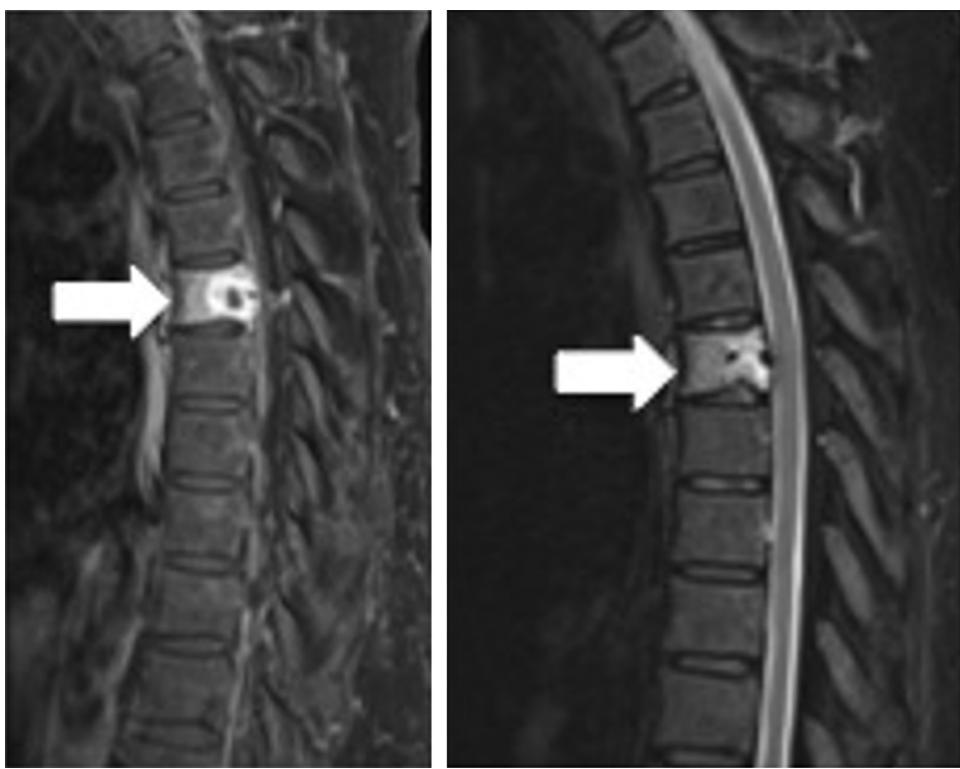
(Left) On follow-up examination 3 months after beginning radiation therapy, there is a new lesion at T6 with similar, avid enhancement on post-contrast T1-weighted image (arrow) as the lumbar lesions. (Right) STIR magnetic resonance imaging image shows signal abnormality at T6 lesion, consistent with disease progression.
